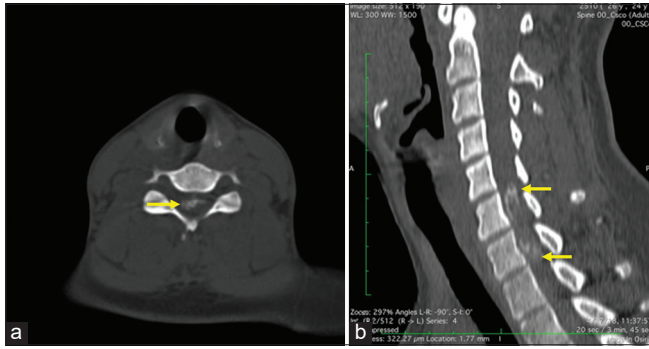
Computed tomography scan of cervical spine demonstrates calcification inside the lesion (arrows) on the axial (a) and sagittal (b) image.
